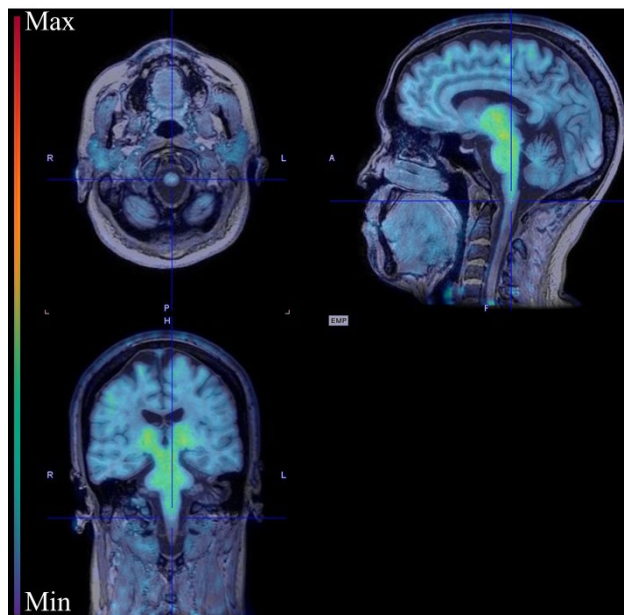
PET image showing timeframe 20 (40-50 minutes), fused with T1-weighted MRI.
